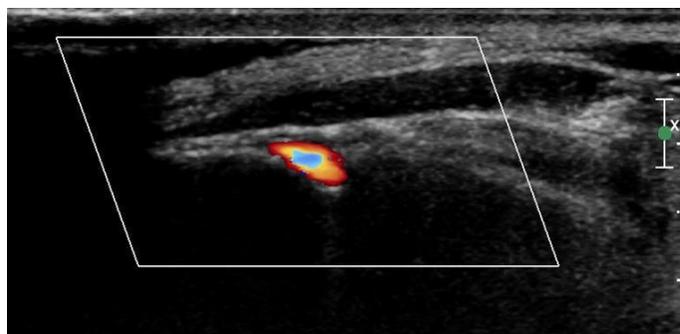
Preoperative Doppler ultrasonography-guided marking of the mastoid emissary vein and its branches.
